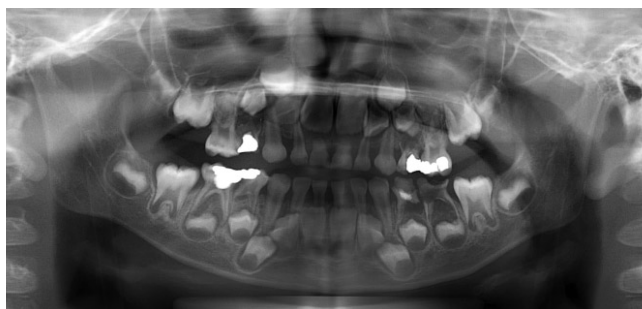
Initial panoramic radiograph. Radiographic examination revealed dental caries, periapical abscesses, and folliculitis. Dental caries were on the maxillary right primary first and second molar, maxillary left primary first molar, mandibular right and left primary first and second molars. And folliculitis was observed on the permanent maxillary right and left first premolars and on the permanent mandibular left first and second premolars.
